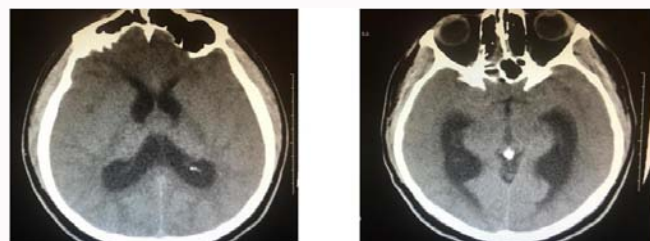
Hydrocephalus and edema in sulcus and gyrus at CT.
